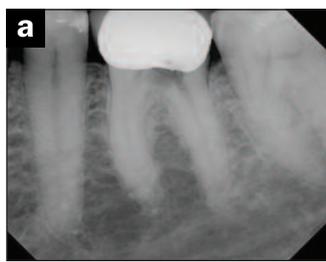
Comprehensive evaluation of resorptive defects is limited with 2-D radiographs.
